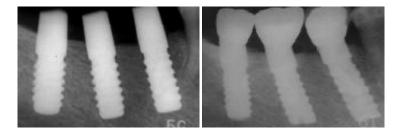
Dental radiographic appearance of implant: Two weeks after the surgery (Left) and 19½ years after the surgery (Right). No signs of bone resorption was observed even after 19 years. (Picture was presented by Dr. Takao Kinebuchi, Kinebuchi Dental Clinic and Dr. Yasuhiko Tsuyama, Mitsui Memorial Hospital).
